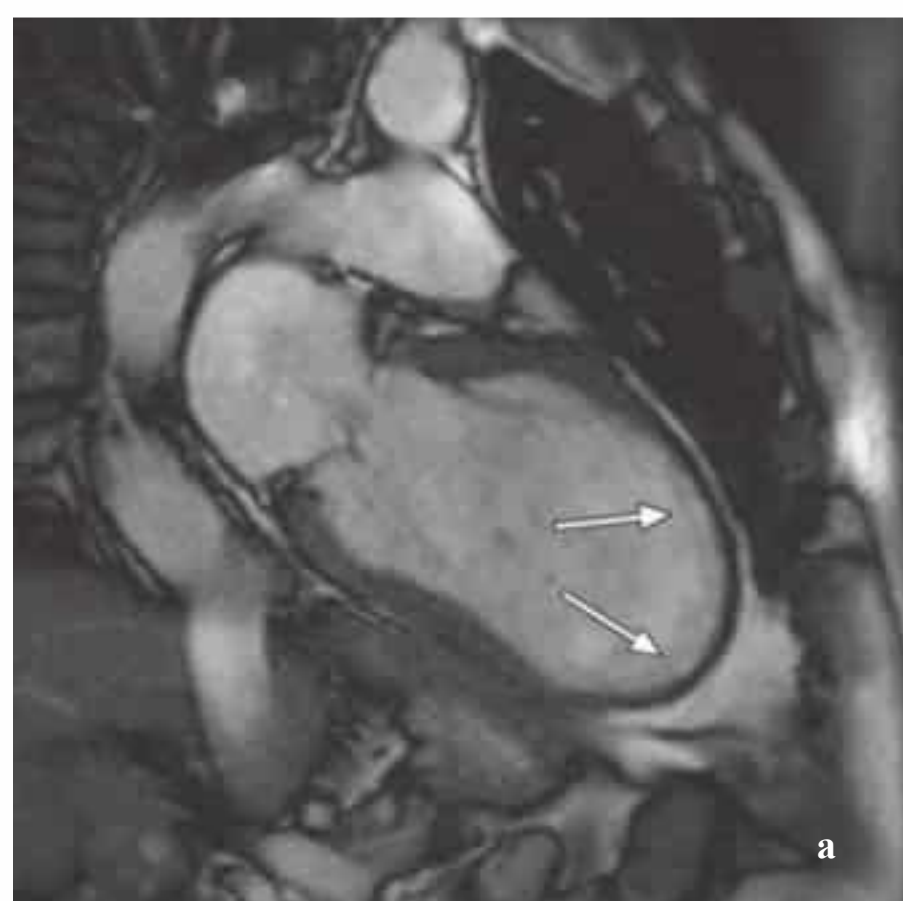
a, b Transmural myocardial scar after an anterior-wall infarction involving the anterior, apical, and inferior apical segments. Resting MRI cine sequence in the two-chamber view at end diastole (a) and end systole (b) shows akinesia and constant wall thinning to 3 mm in segments 7, 13, 15, and 17 (arrows) with severe impairment of LV global function. Subsequent late-enhancement images (not shown) confirmed a transmural scar.
